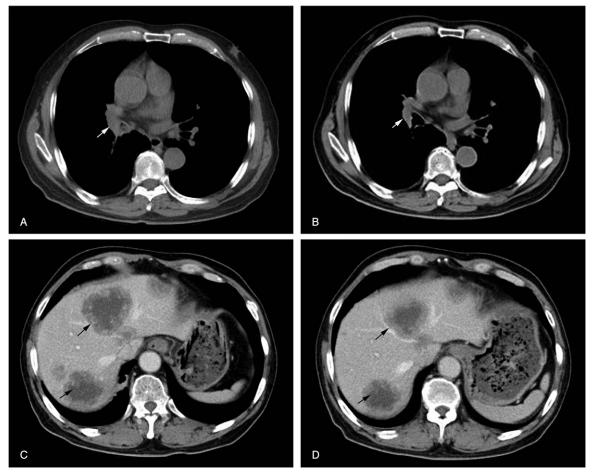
Primary lung lesions and liver metastases on CT scans. (A) Right hilar lesion before chemotherapy. (B) Right hilar lesion shrunk after chemotherapy. (C) Multiple metastatic tumors in liver. (D) Reduction of multiple liver lesions happened after chemotherapy. CT = computed tomography.
